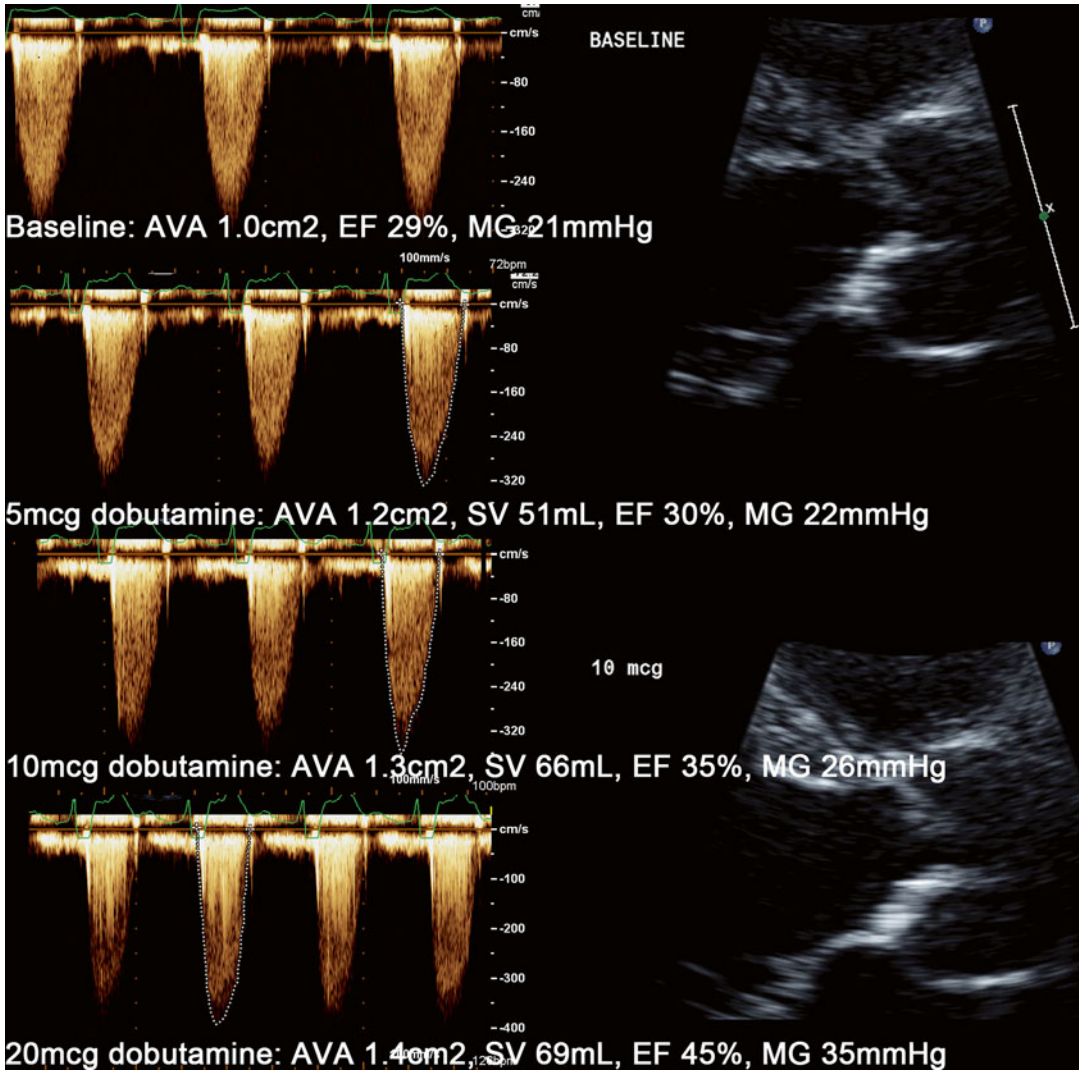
Dobutamine stress echocardiography. From top to bottom; at baseline, 5 mcg, 10 mcg, and 20 mcg of dobutamine. Note how the stroke volume, gradient, and aortic valve area are increasing. Note how the aortic valve on 2D echocardiography appears to be opening further with increased flow
